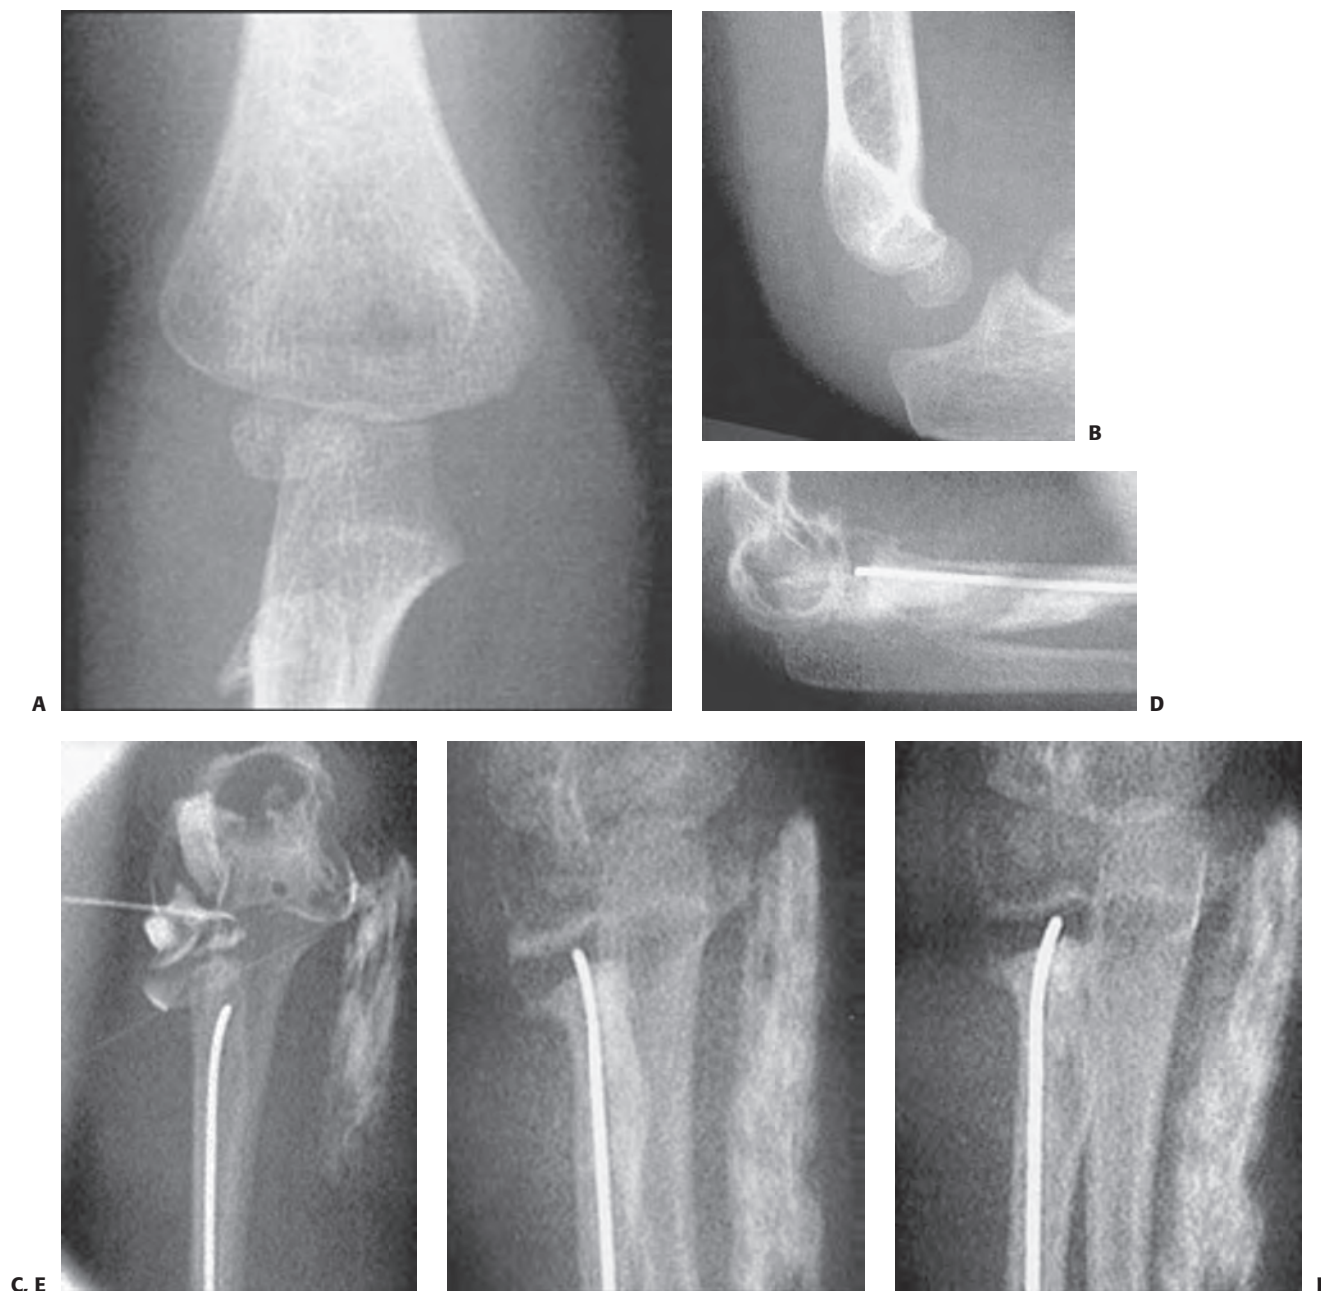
A, B: AP and lateral radiographs demonstrating a radial neck fracture in a patient with a nonossified proximal radial epiphysis. C: Arthrogram prior to reduction demonstrating location/displacement of nonossified proximal radial epiphysis. D–F: Arthrogram/radiographs after reduction with intramedullary technique. (From Javed A, Guichet JM. Arthrography for reduction of a fracture of the radial neck in a child with a nonossified radial epiphysis. *J Bone Joint Surg Br.* 2001;83-B:542–543, with permission.)
